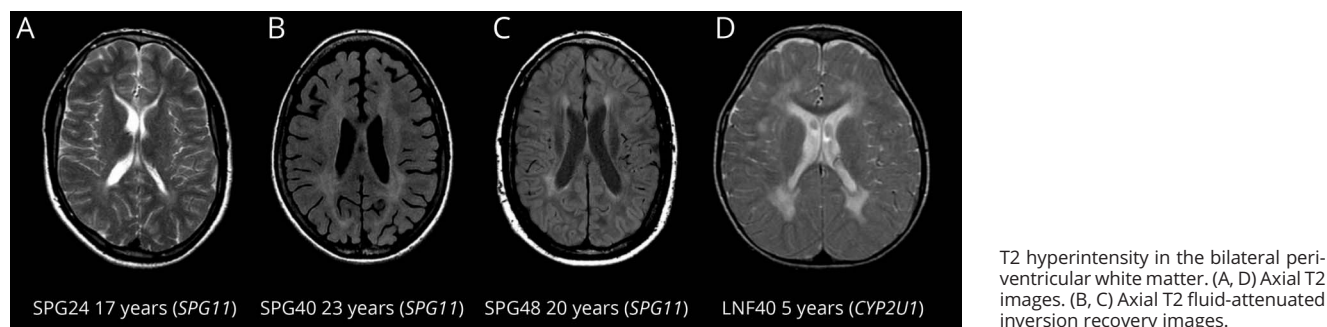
MRI Findings in Patients With New/Atypical and Blended Phenotypes
